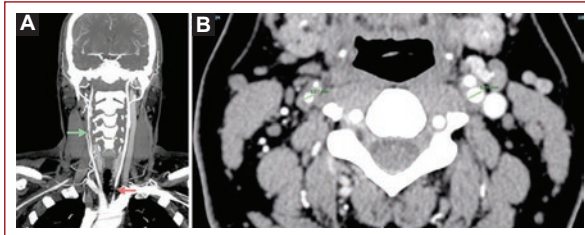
A and B: computed tomography angiography, coronal view demonstrated focal stenosis in the right common carotid artery (CCA) (green arrow) and near occlusion of the proximal left CCA (red arrow). Axial view shows focal stenosis in the right internal carotid artery (black hollow arrow). (*Reproduced with permission from Elsevier from Hinojosa et al.².*)
